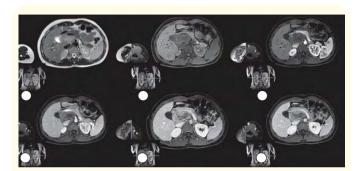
MRI-imaging of the pancreatic head lesion: a - T2 WI; b - eTHRIVE native; c-e - eTHRIVE with contrast enhancement sequentially.
